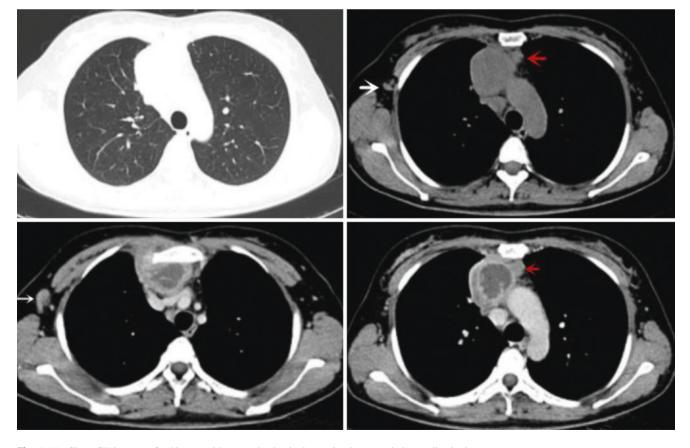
Chest CT images of a 40-year-old woman's physical examination revealed a mediastinal mass
